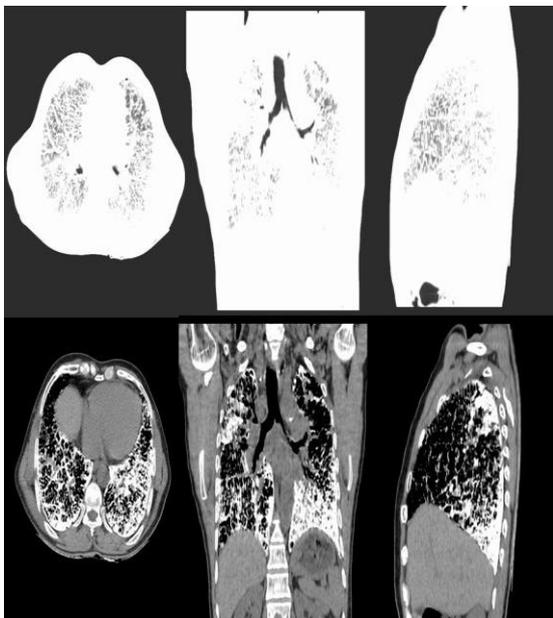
HRCT image lung window (upper row) and mediastinal window (lower row) in axial, coronal and sagittal reformat showing widespread nodular intra-alveolar calcific density with diffuse ground-glass attenuation, calcifications along the interlobular septa, bronchovascular bundles and subpleural regions, more pronounced in lower and posterior pulmonary regions.
